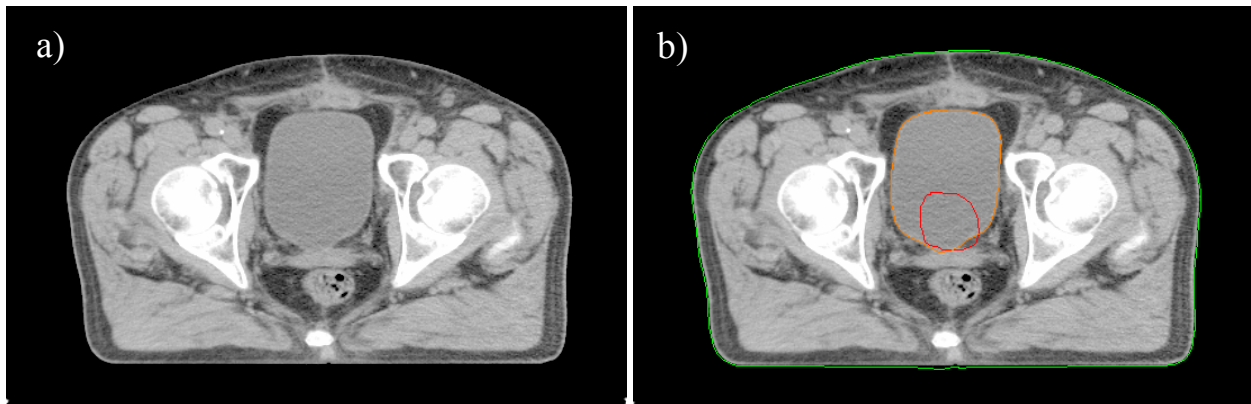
a) An axial CT slice through a pelvic region b) A clinical target (red contour) and the bladder (orange contour) in relation to the external contour (green contour) are delineated to be used in treatment planning.
